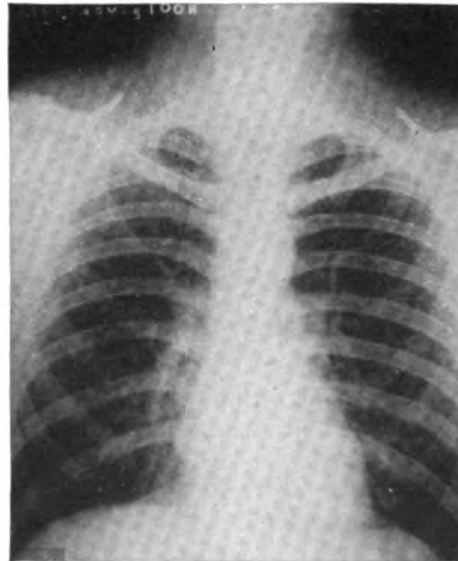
Chest roentgenogram taken 2 September 1948.
